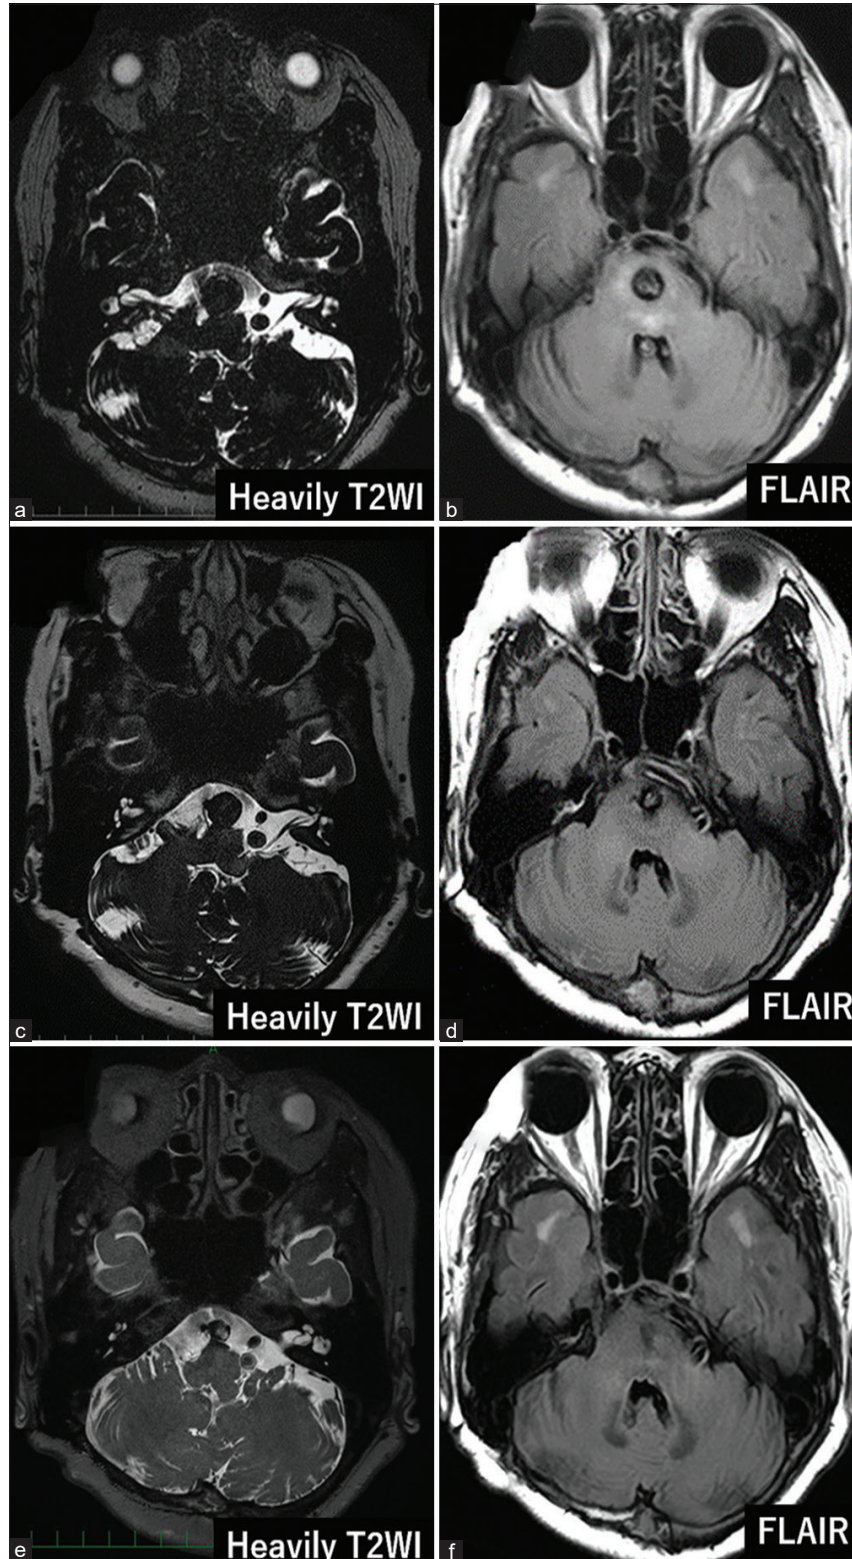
Imaging findings long after the treatment. (a) Magnetic resonance (MR) image at 6 months postoperatively showing increased aneurysm size (15 mm), (b) MR image at 12 months postoperatively showing decreased aneurysm size (12 mm), (c) MR image at 33 months postoperatively showing further decreased aneurysm size (10 mm), (d) MR image at 6 months postoperatively showing persisting brainstem mass effect, (e) MR image at 12 months postoperatively showing no brainstem mass effect, (f) MR image at 33 months postoperatively showing no brainstem mass effect.
